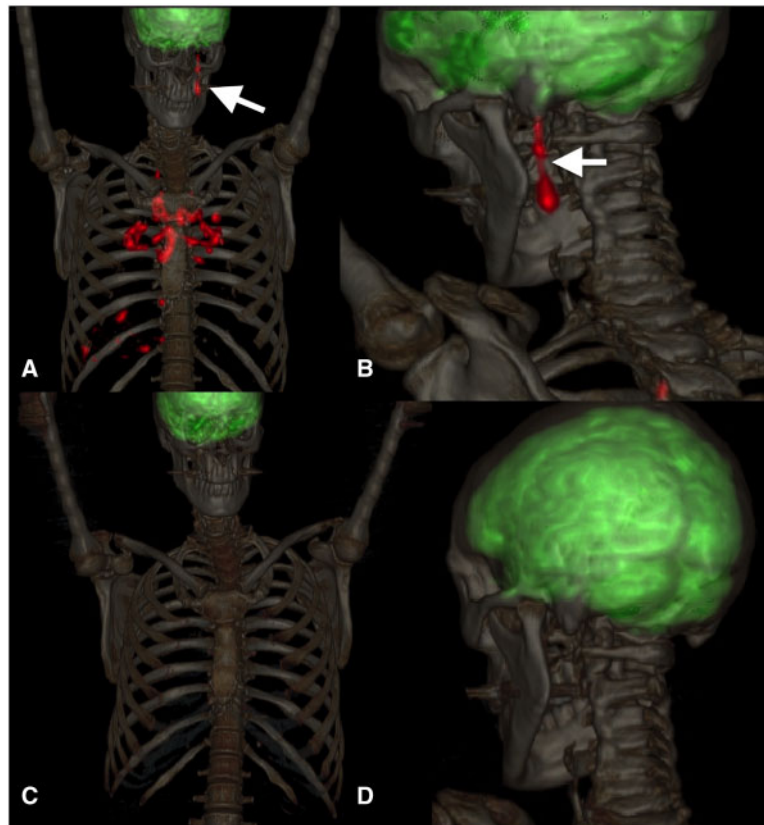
The 3D reconstruction of ^{18}F FDG PET/CT images revealing ^{18}F FDG uptake of mediastinal lymph nodes, liver nodules, the emergence of left glossopharyngeal and vagus nerves and the upper cervical ganglion related to sarcoidosis (A, arrow, zoomed in B, standardized uptake value of 8.4), with a complete remission at 6 months under infliximab therapy (C, zoomed in D).
